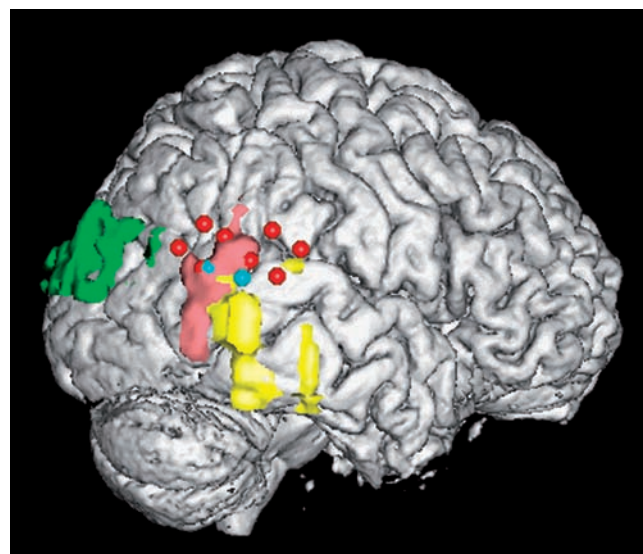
Lesion analysis of patients with documented brain anomalies and OBE. Mean lesion-overlap analysis of five neurological patients with OBE in whom a lesion could be defined (Patients 1, 2, 3, 5, and 6 from [7]). The MRI of all patients was transformed into Talairach space and projected on the MRI of one patient. Each colour represents a different OBE patient. Mean overlap analysis centred on the TPJ. For details, see [7] and [24]. *Source:* Modified from Blanke *et al.* [7], reproduced with permission from Oxford University Press.
